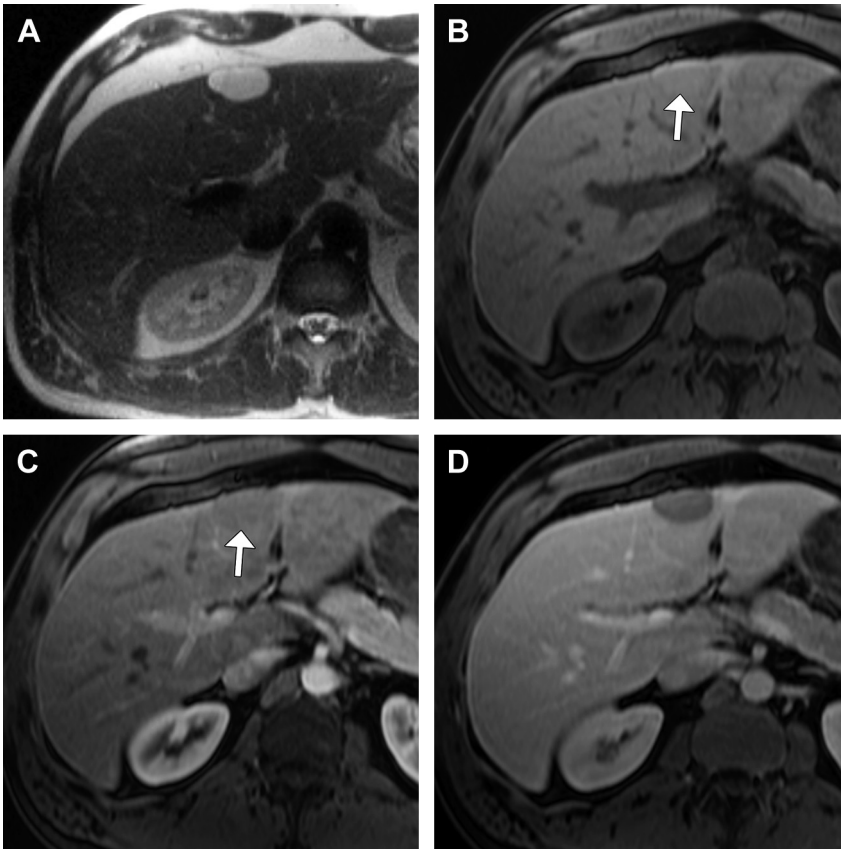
Ciliated hepatic foregut cyst. (A) Typical subcapsular T2 hyperintense cystic lesion in segment 4 extends slightly beyond the contour of the liver. (B) On precontrast fat-suppressed T1-weighted imaging, this appears isointense to liver due to proteinaceous fluid content (arrow). (C) The lesion remains nearly isointense to adjacent liver parenchyma during arterial phase (arrow). (D) It becomes hypointense to liver during the portal venous phase but should not be mistaken for a solid enhancing lesion with “washout.”
